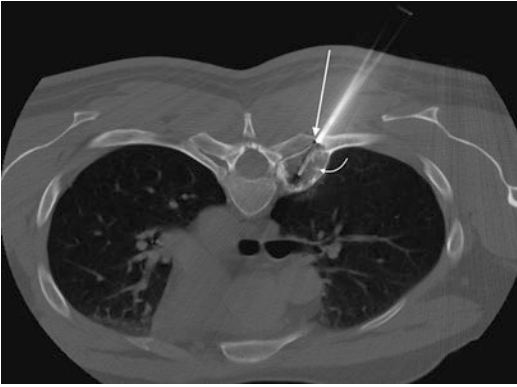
A 34-year-old male with upper back pain. Axial CT image from a rib biopsy procedure, with the patient in the prone position, shows coaxial placement of a guide needle (*arrow*) at the notch between the transverse process and rib; this is a posterior approach with a medial trajectory for this medial lesion. A trephine bone biopsy needle is advanced into this expansile lytic lesion within the rib head and neck that contains small calcific foci (*curved arrow*). The pathologic diagnosis was chondrosarcoma
